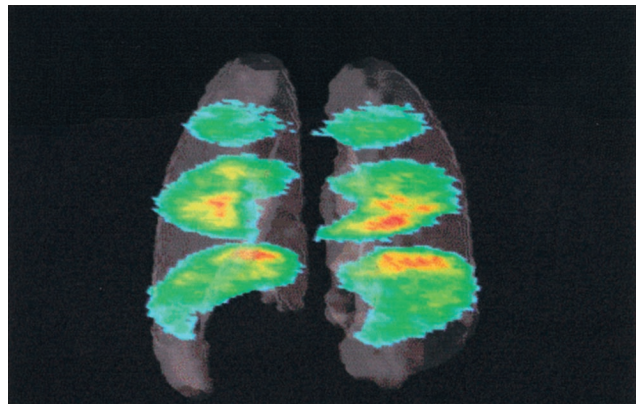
Relationship of the single-photon-emission computed tomography (SPECT) images with the lung boundary model. Airways of a branching model inserted within the boundary could be associated with a particular region of a SPECT image.
